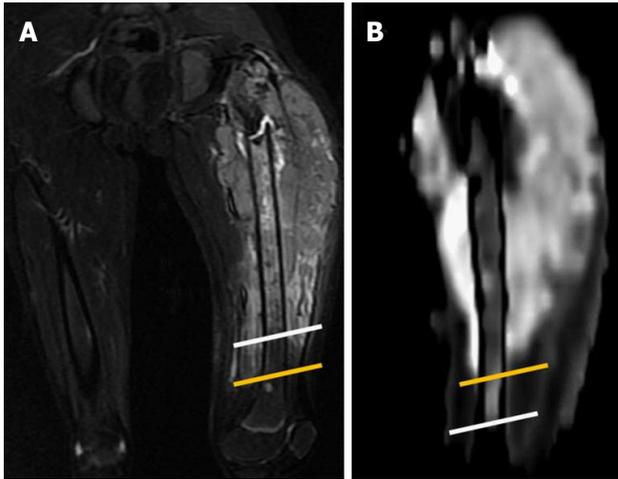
Case of Ewing's sarcoma in a 12-year-old boy. A: Coronal T2W-FS image showing altered marrow signal intensity in the femoral diaphysis (white line representing inferior extent) with associated soft tissue mass and surrounding edema (yellow line representing inferior extent); B: DWI shows restricted diffusion in the involved marrow which was significantly less (inferior extent represented by the white line) than that noted on the T2w Images thus differentiating the marrow edema from marrow infiltration and soft tissue edema from infiltration (yellow line representing inferior extent). The soft tissue mass shows restricted diffusion, suggestive of infiltrative tumor mass and not reactive inflammation. DWI: Diffusion-weighted imaging.
